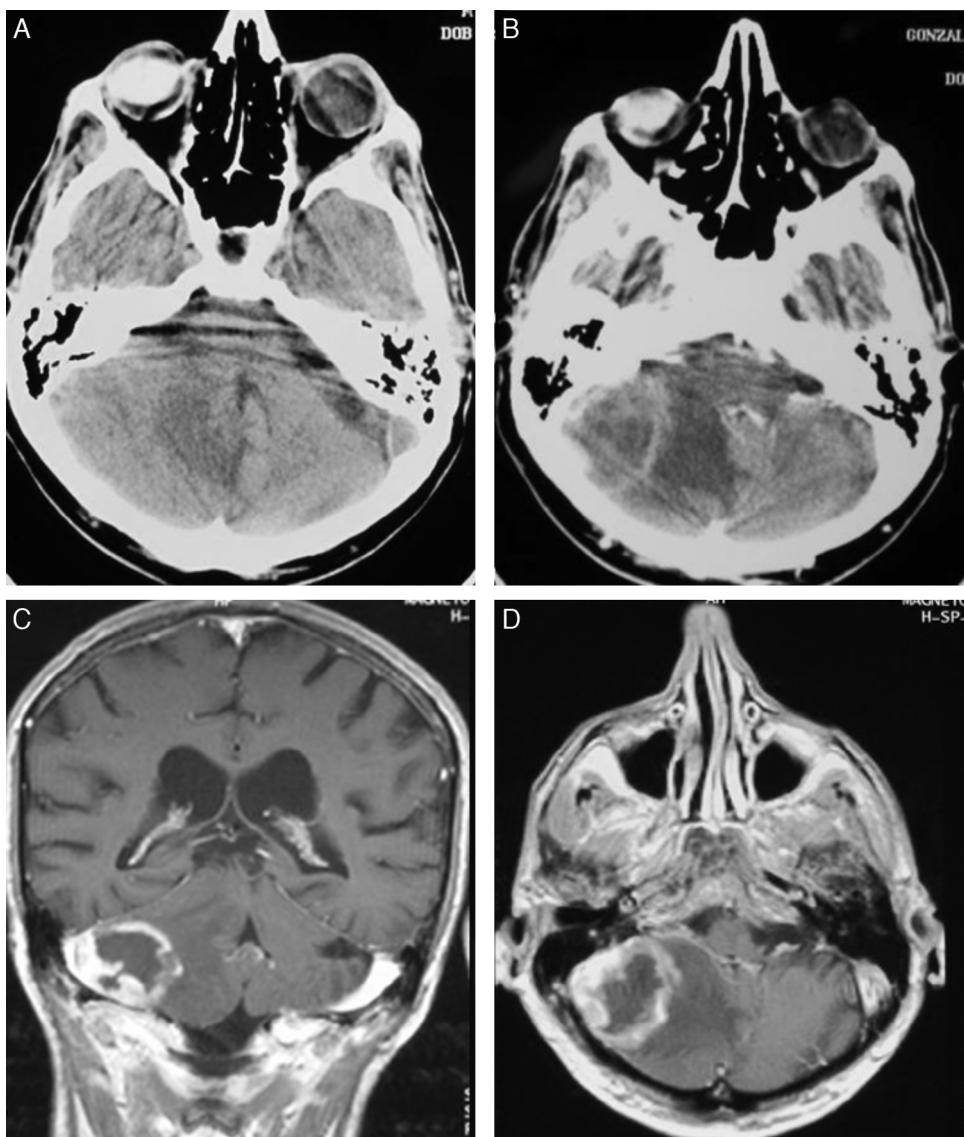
(A and B) CT with and without contrast showing a lesion in the right cerebellar hemisphere. (C and D) Contrast MRI corresponding to the same patient (Patient 18).
